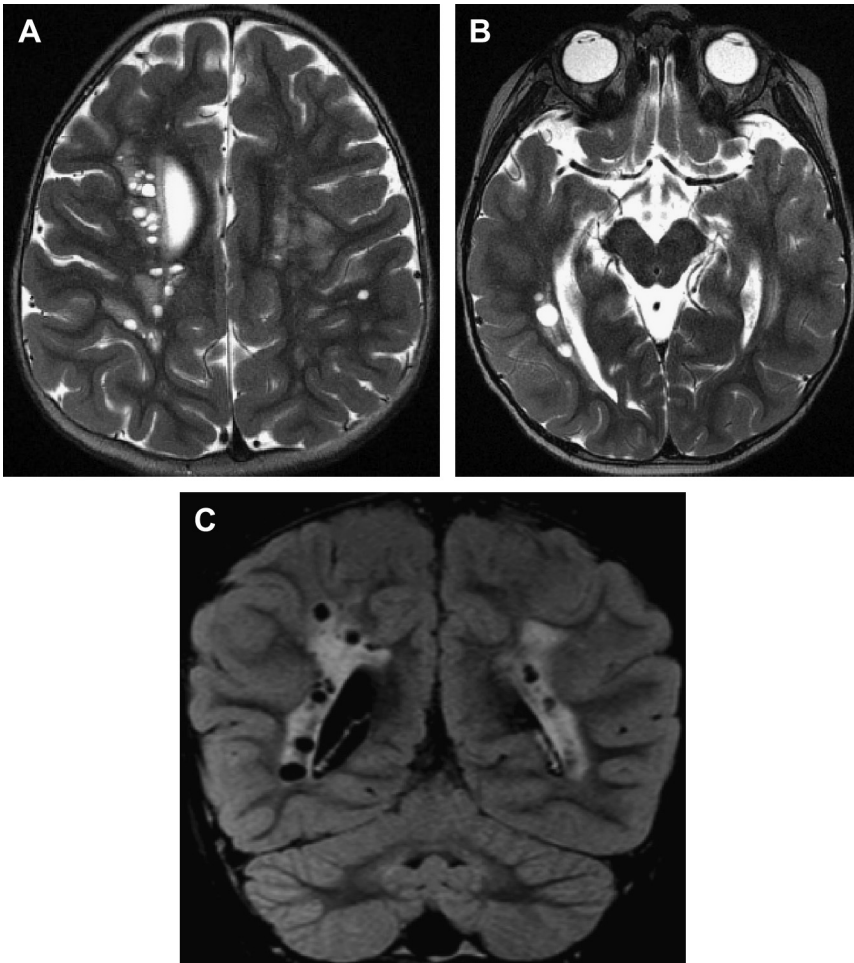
Four-year-old with Lowe syndrome (seizure, Fanconi syndrome, cataracts). Axial T2 images (A, B) and coronal FLAIR (C) demonstrate periventricular signal abnormality with interspersed areas of cystic change. Note the lens prostheses in B from previous cataract surgery.
